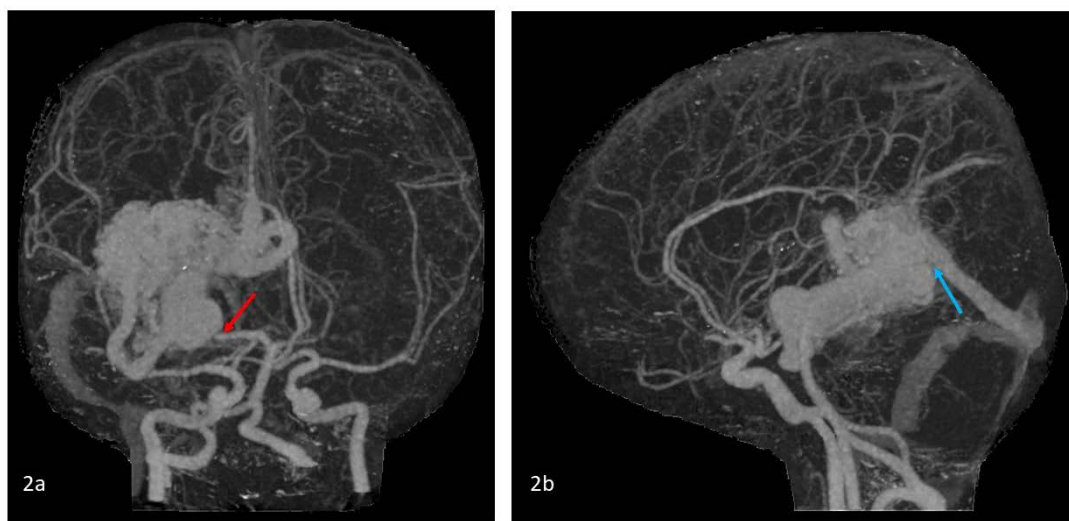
Bag of worms sign. 54 year old male with large cerebral arteriovenous malformation. CT angiography of the Circle of Willis 3D volume-rendered reconstruction shows that the arteriovenous malformation is primarily supplied by the right posterior cerebral artery (PCA) (red arrow in 2a) and drains via the vein of Galen and straight sinus (blue arrow in 2b). Toshiba Aquilion One, Slice width 3.0 mm, 120 kV, 114 mAs, Intravenous contrast: 60 ml Omnipaque
